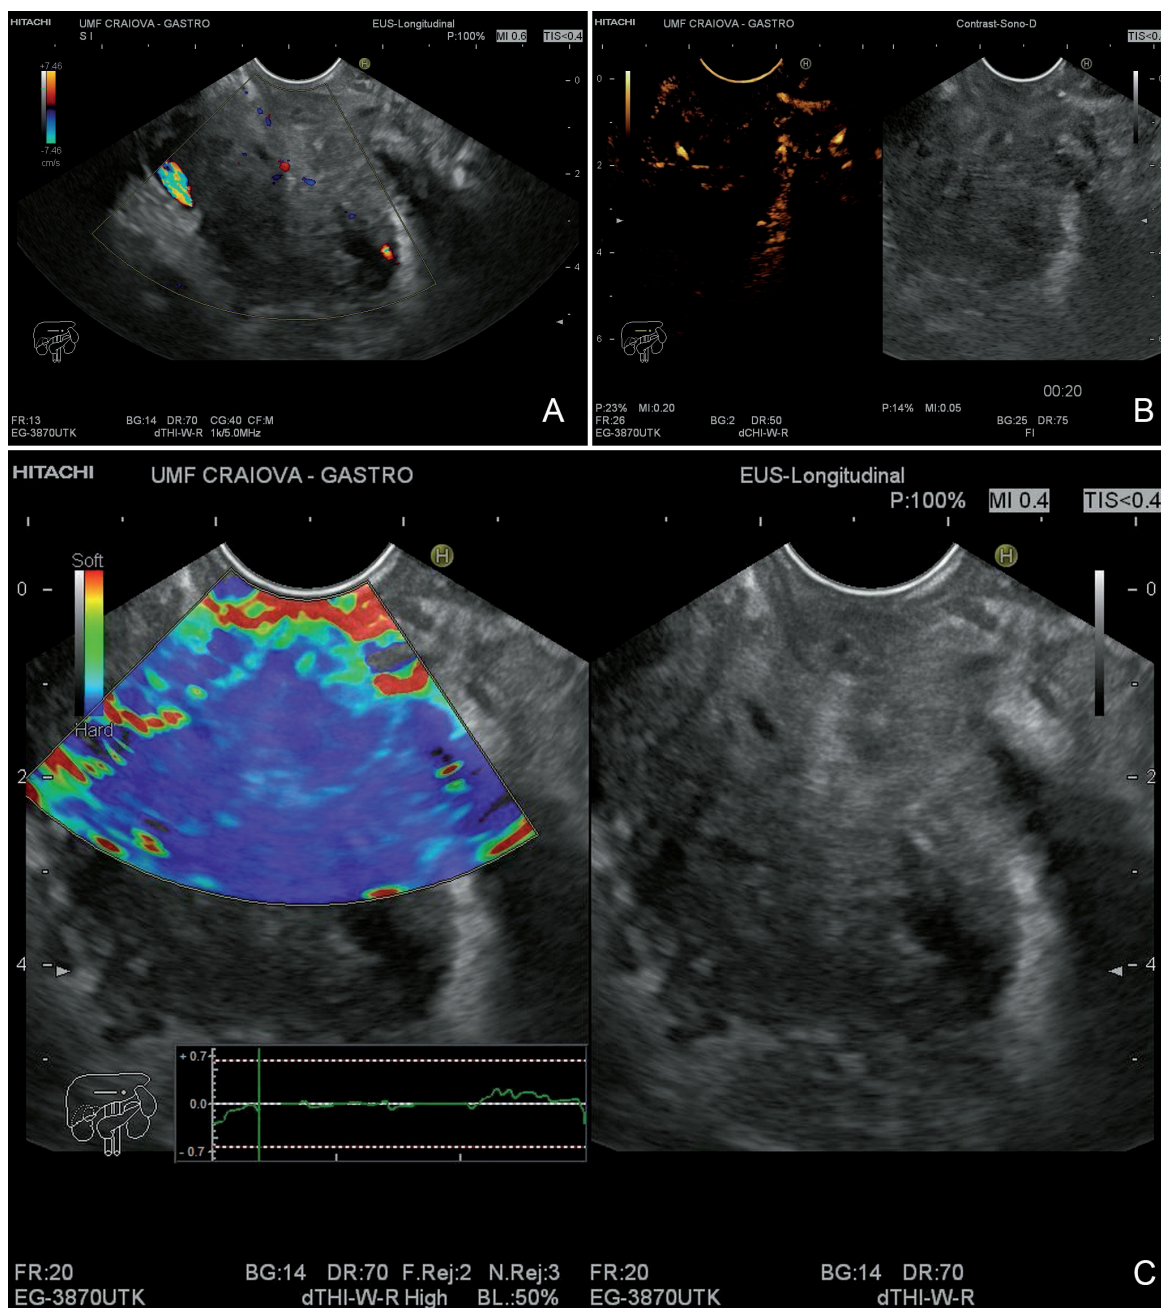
Multimodal EUS imaging of a solid pancreatic tumor, pancreatic adenocarcinoma. A EUS – Doppler imaging. B Contrast-enhanced ultrasound imaging. C. EUS-E imaging with strain histogram.
